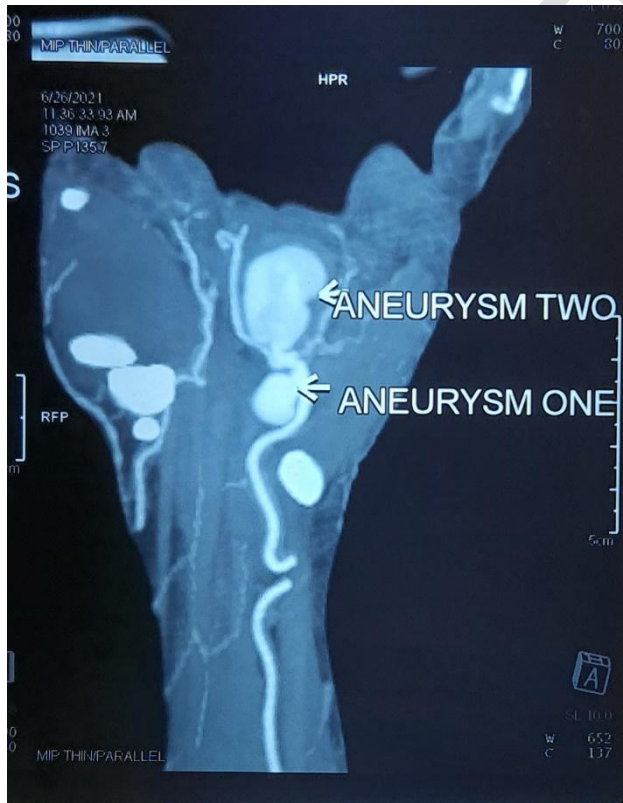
CT angiogram of left hand showing multiple aneurysms of ulnar artery with incomplete palmar arch
